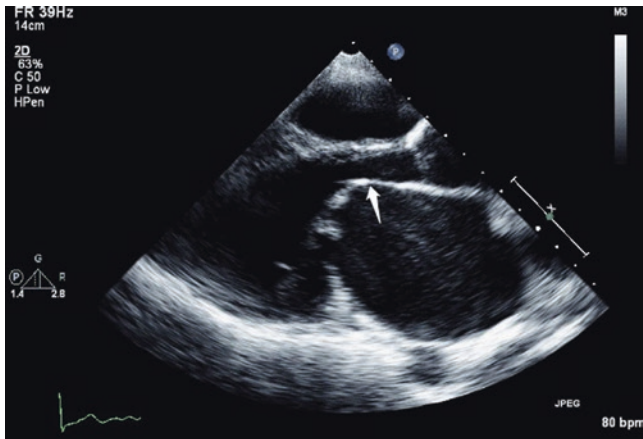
This is an echocardiogram image from a patient with rheumatic mitral stenosis. Note the anterior mitral valve (arrow) with the characteristic “hockey stick” appearance
